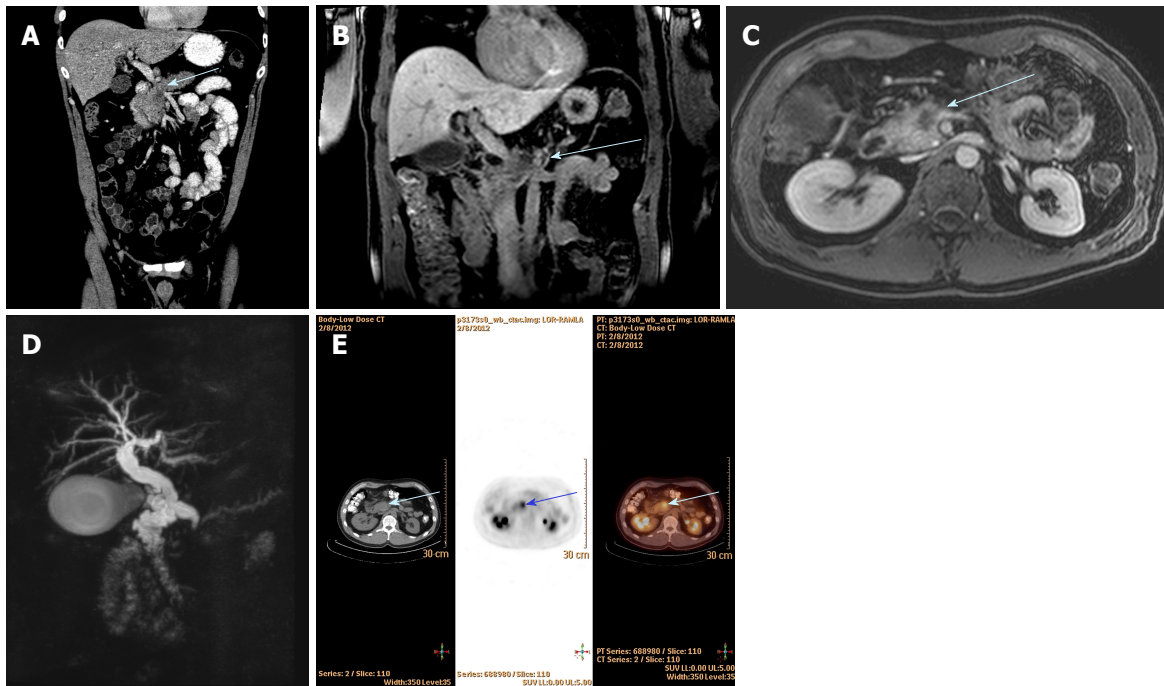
Multimodal imaging techniques utilised for a patient with 2.8 cm head of pancreas cancer (blue arrow) with portal vein and superior mesenteric vein invasion. A: Hypodense mass on coronal view on CT; B: T1-weighted coronal view on MRI; C: T1-weighted axial view on MRI; D: MRCP view with dilated CBD and PD (double duct sign); E: Axial view on PET CT imaging showing marked FDG avidity. CT: Computed tomography; MDCT: Multi-detector computed tomography; MRI: Magnetic resonance imaging; PET: Positron emission tomography; MRCP: Magnetic resonance cholangiopancreatography; FDG: Fluorodeoxyglucose.
